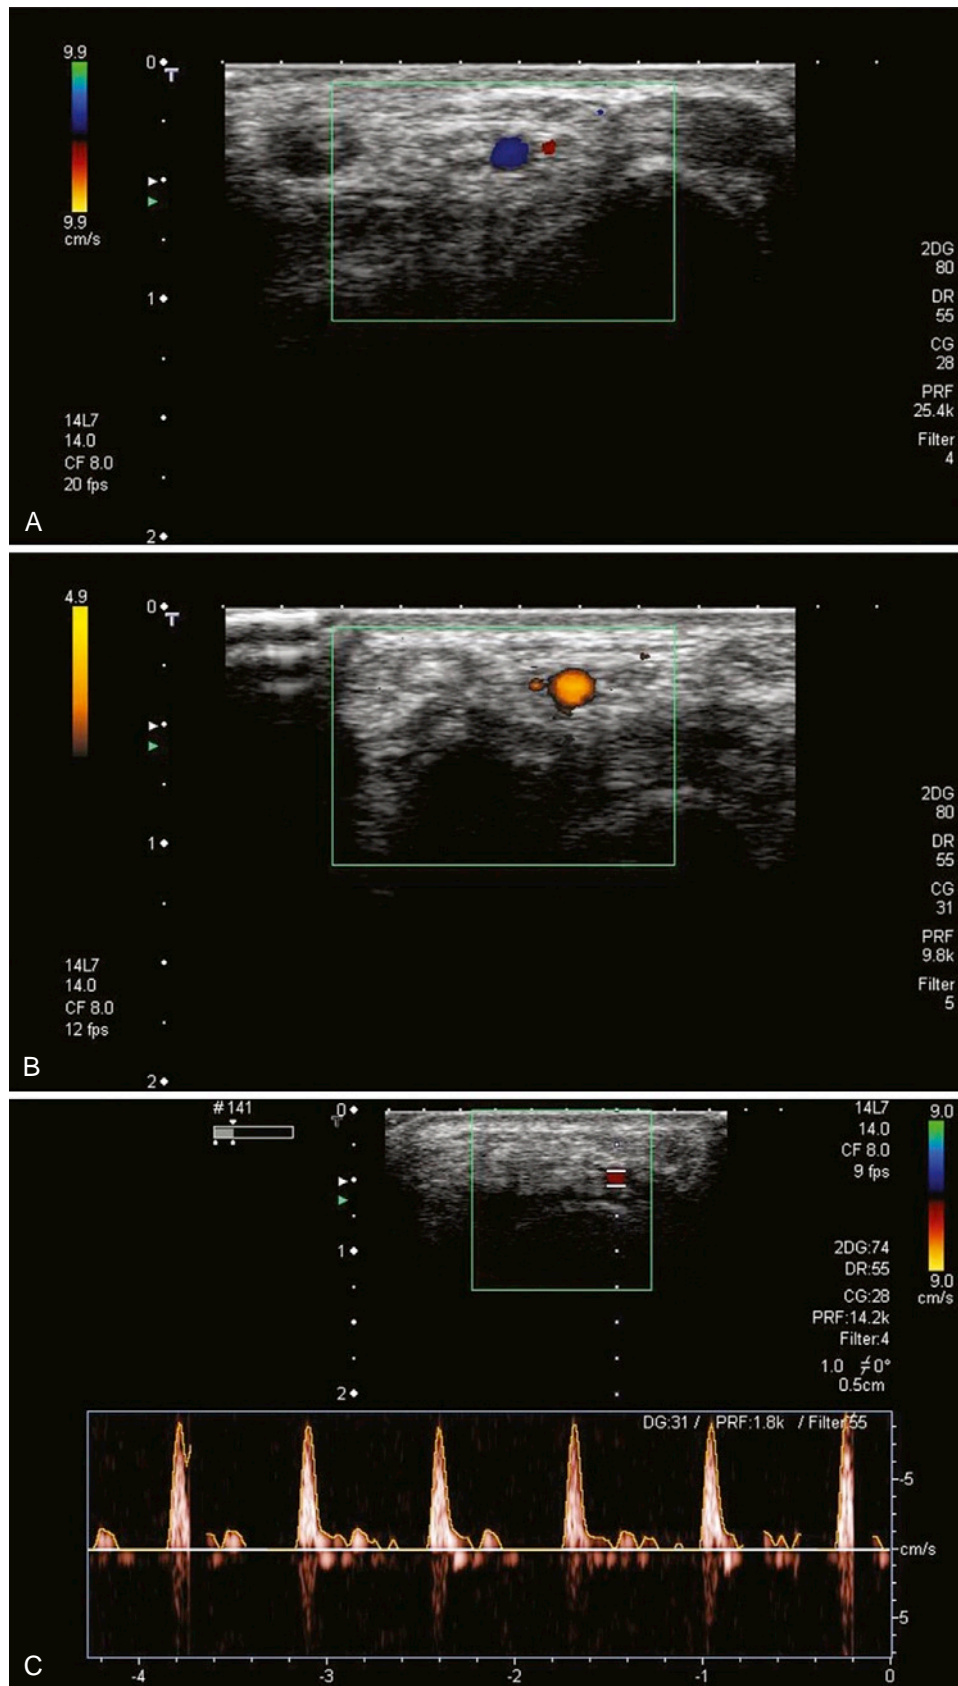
DOPPLER DISPLAY IMAGES OF THE RADIAL ARTERY. A, Color display is shown for dynamic flow imaging. The direction of movement is shown in *red* (away from the transducer) and *blue* (toward the transducer). Color hue also conveys information related to relative speed (i.e., larger or smaller Doppler shifts) on this display scale. B, In a power Doppler display of the same vessel, the information concerning velocity and direction is lost, but higher sensitivity for flow detection can be obtained. C, A measurement gate is placed on the two-dimensional image (*insert*) to select a region for pulsed-wave Doppler evaluation. Along the bottom of the image, the velocity estimated from the Doppler shift is displayed on the y-axis as a function of time. Variation of the flow during the heart cycle can be visualized.
